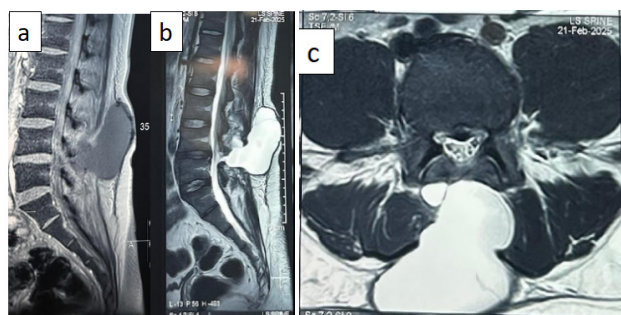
MRI of lumbosacral region showing a) T1 weighted sagittal image showing hypointense swelling b) T2 weighted sagittal image showing hyperintense swelling c) T2 weighted axial image showing hyperintensity of the swelling suggestive of post-operative giant pseudomeningocele.
